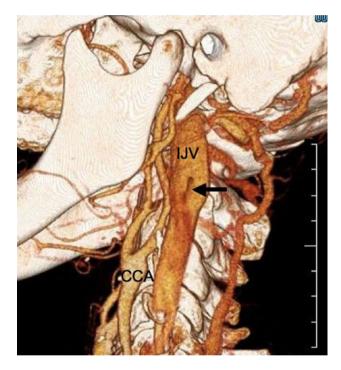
3D-CT shows the fenestrated IJV (arrowhead) clearly
